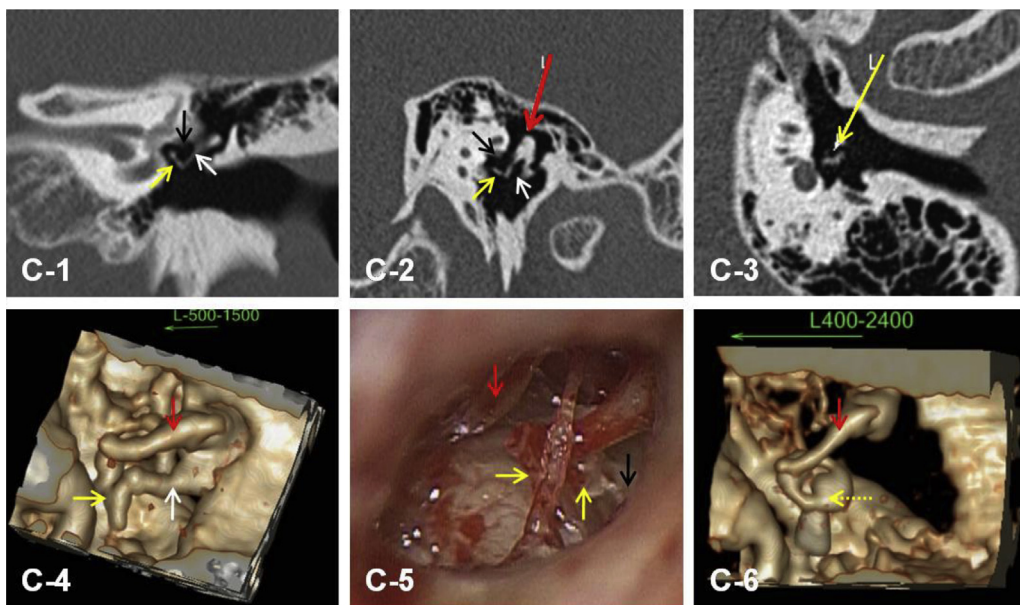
C-2: Coronal section plane of conventional CT; C-3 and B-4: MPR imaging; C4 preoperative CTVR imaging; C-5: surgical image; C-6: post-operative CTVR imaging. Red arrow—hand of malleus; white arrow—long limb of incus; yellow arrow—abnormal stapes superstructure and PORP(C-6); black arrow—facial nerve.
